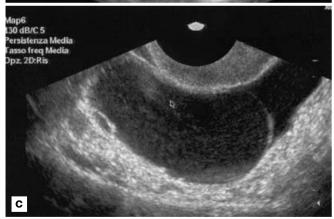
Ultrasound of ovarian neoplasms. a Transabdominal scan of serous cyst adenoma containing only few and relatively thin septa, without parietal vegetations. b Transabdominal view of serous cyst adenocarcinoma characterized by multiple, thick, and irregular septa. c Transvaginal appearance of mucinous adenoma presenting thin septa and finely corpusculated fluid
